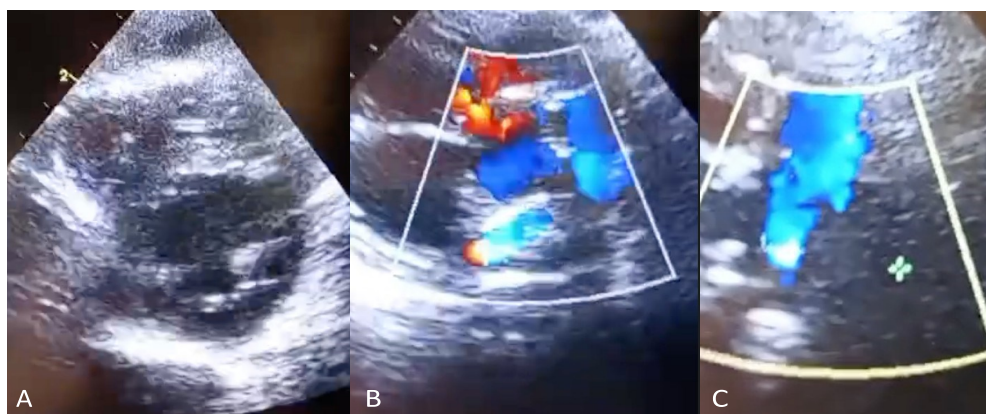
Control echocardiogram. (A) LV short axis; (B) Flow through the stent in RPB; (C) VD-AP tube and connection with RPB.
